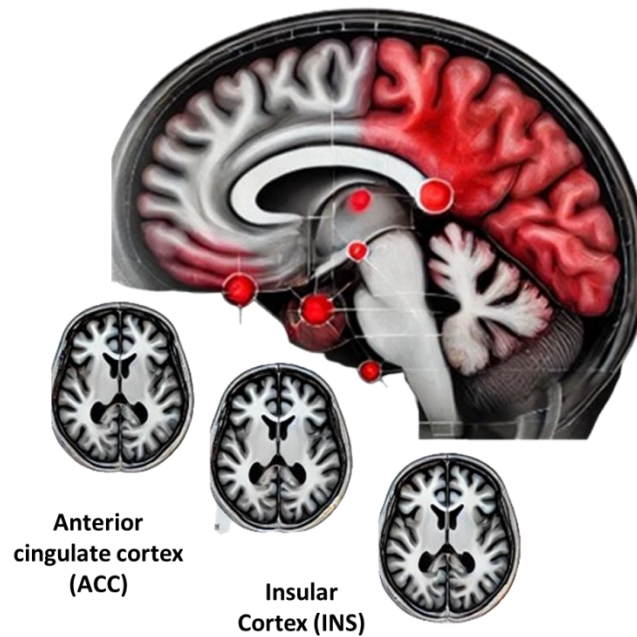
MRI Brain Scans of Pain Processing Regions*
